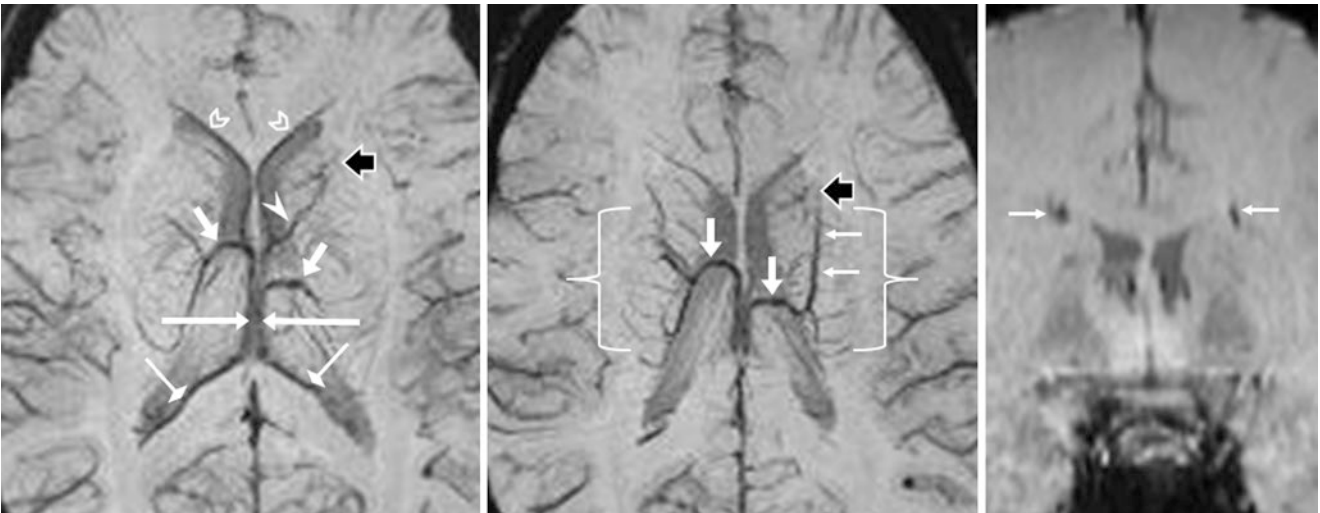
This 15-year-old had a 3 T MRI to follow up an incidental developmental venous anomaly (DVA). 12 mm thickness axial SWIs (*left and middle*) and a 2 mm thickness coronal SWI (*right*) depict normal venous anatomy, with a “caput” of the DVA (*wide dark arrows*), perhaps draining via the ACV (*arrowhead*). Note normal, asymmetric
